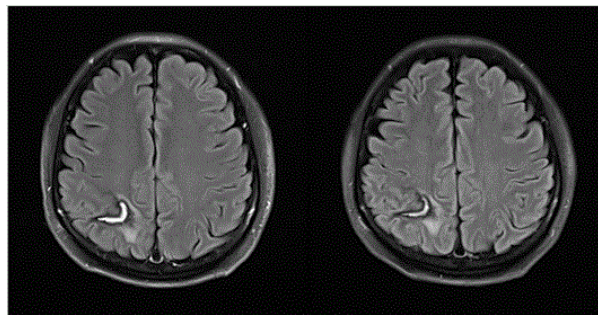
(a) Cerebral MRI 3days before Nelarabine start. Encephalomalatic change of known ICH in Rt. parietal lobe and peri-lesional edema. (b) Cerebral MRI 1 week after Nelarabine start and 2 days after generalized tonic-clonic seizure. No significant change and no evidence of tumor invasion in brain.
